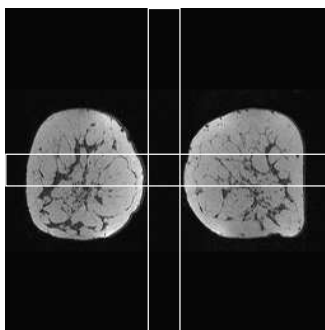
Selected breast volume indicated on an axial slice of the MRI volume (a). Axial slice of an MRI examination that was not included in the data set because of the distribution of the glandular tissue (b).*
